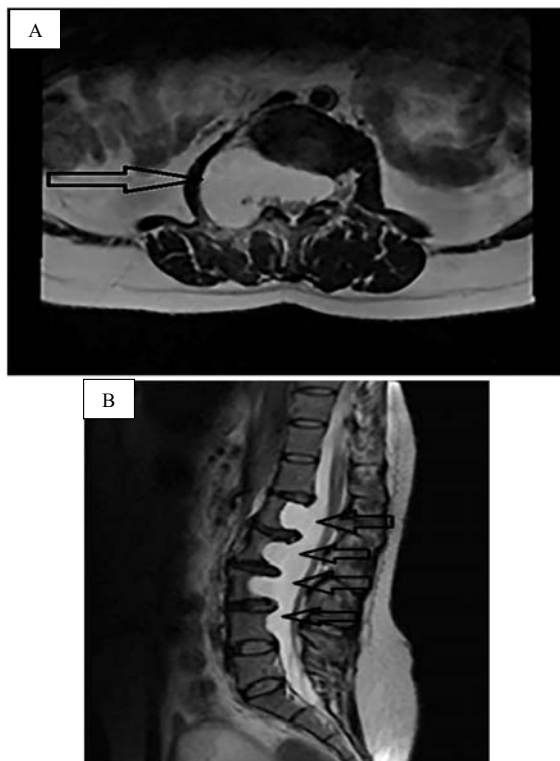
Magnetic resonance imaging (MRI) study of the patient; A: T2-weighted axial section of L2 vertebra shows severe dural ectasia, lateral meningocele formation; and posterior body scalloping; B: T2-weighted mid-sagittal section of the lumbosacral spine showing dural ectasia and posterior body scalloping despite acceptable sagittal balance at L1-L4
